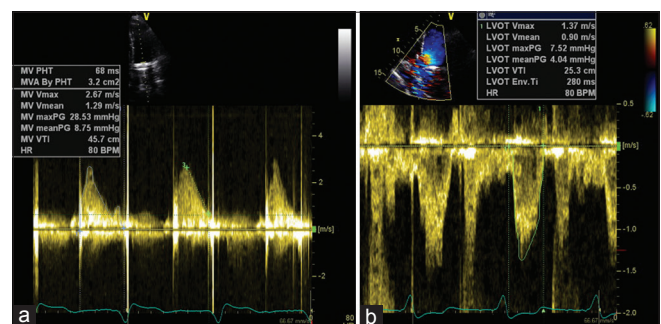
Follow-up echocardiography. (a) The mitral mean gradient 8.7 mmHg peak gradient 25 mmHg, pressure half-time of 68 ms, and (b) the VTImv/VTIlvot = 1.8, indicating a normal prosthetic valve function
